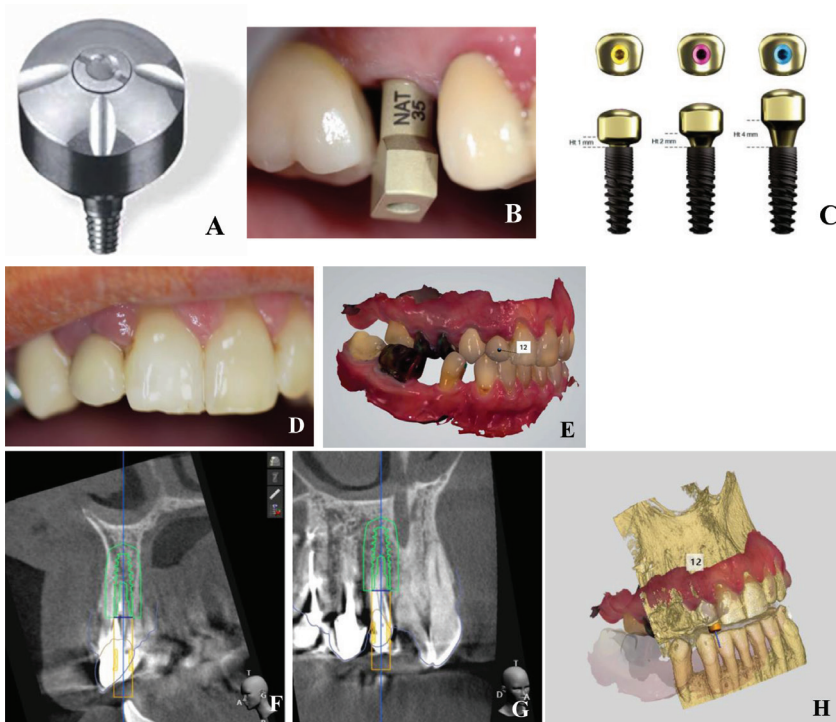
A. Implants, B. Biomet 3I Encode system, C. Implant Ht 1 mm, Ht 2 mm, Ht 4 mm, D. Intra-oral examination, E. DICOM CB-CT (OP300 instrumentarium), F. The planification of the case, G. Modelization of the surgical stent using the software, H. 3D FormLab printer
